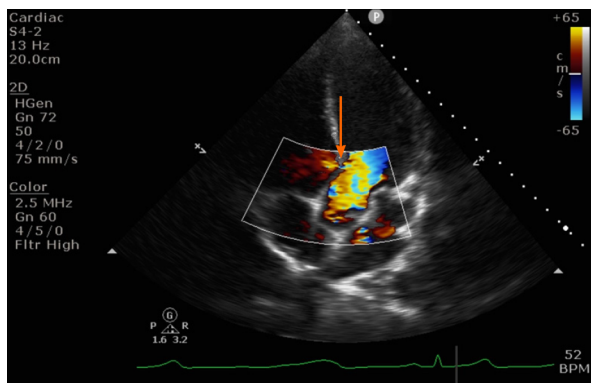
Transthoracic echocardiography apical 4 chamber view showing a small peri membranous ventricular septal defect with a left to right shunt (orange arrow).
